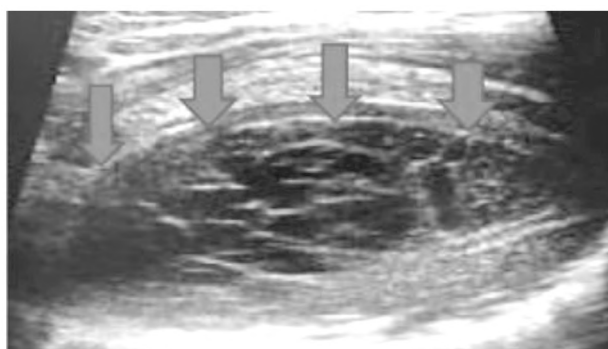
Empyema in a 40-year-old male with fever and dyspnea. Ultrasound: Showing thick, septate pleural collection with loculations and echogenic debris (blue arrows).
